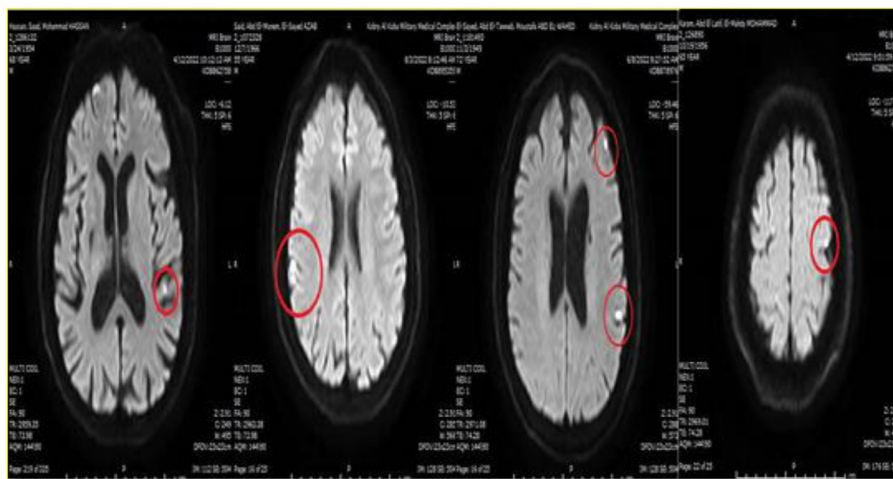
Postprocedure diffusion-weighted magnetic resonance imaging findings.
